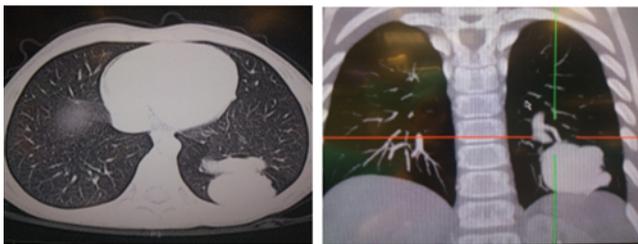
CT Chest that shows the existence of a large AV malformation in the area of the lower left lungs.
